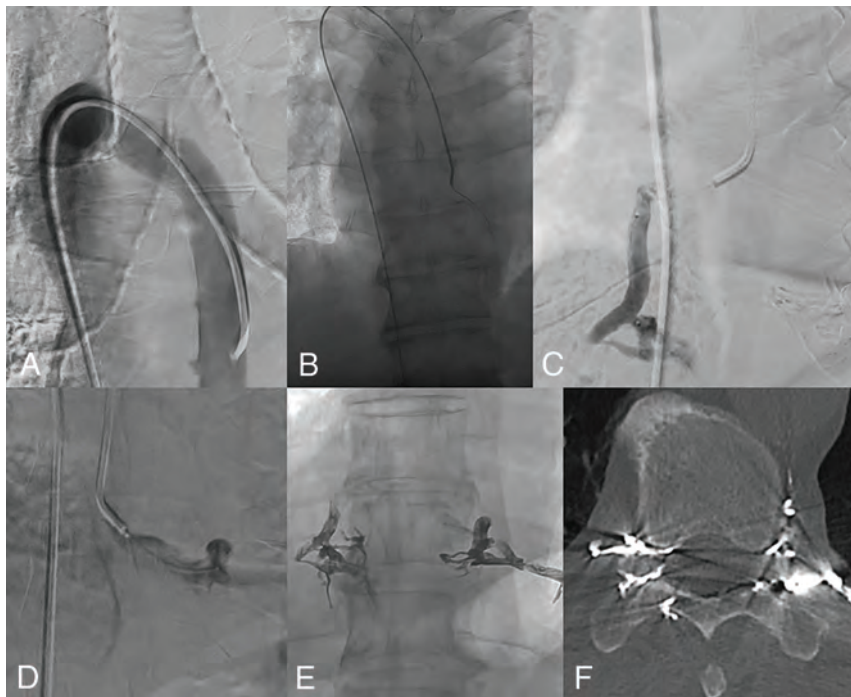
Steps involved in CSF-venous fistula embolization (patient 5). *A*, The azygous vein is selectively catheterized using a 5F Vertebral catheter. The catheter is directed posteriorly to face the azygous vein. In this case, the patient had to take a shallow inspiration to open up the valve between the azygous vein and the superior vena cava. *B*, The catheter is then advanced into the azygous vein over a stiff Glidewire. This support is needed for the catheter to make the 180° turn. *C*, This patient had bilateral CSF-venous fistulas at the right T9. We advanced a Headway Duo microcatheter into the right T9 paraspinal vein, and a venogram was performed. The same procedure was performed for the left T9 paraspinal vein (*D*). *E*, Both veins are embolized with Onyx 34 to build a plug followed by Onyx 18. *F*, Postoperative CT shows excellent filling of the radicular veins at T9 bilaterally, essentially sealing off the CSF-venous fistulas.
